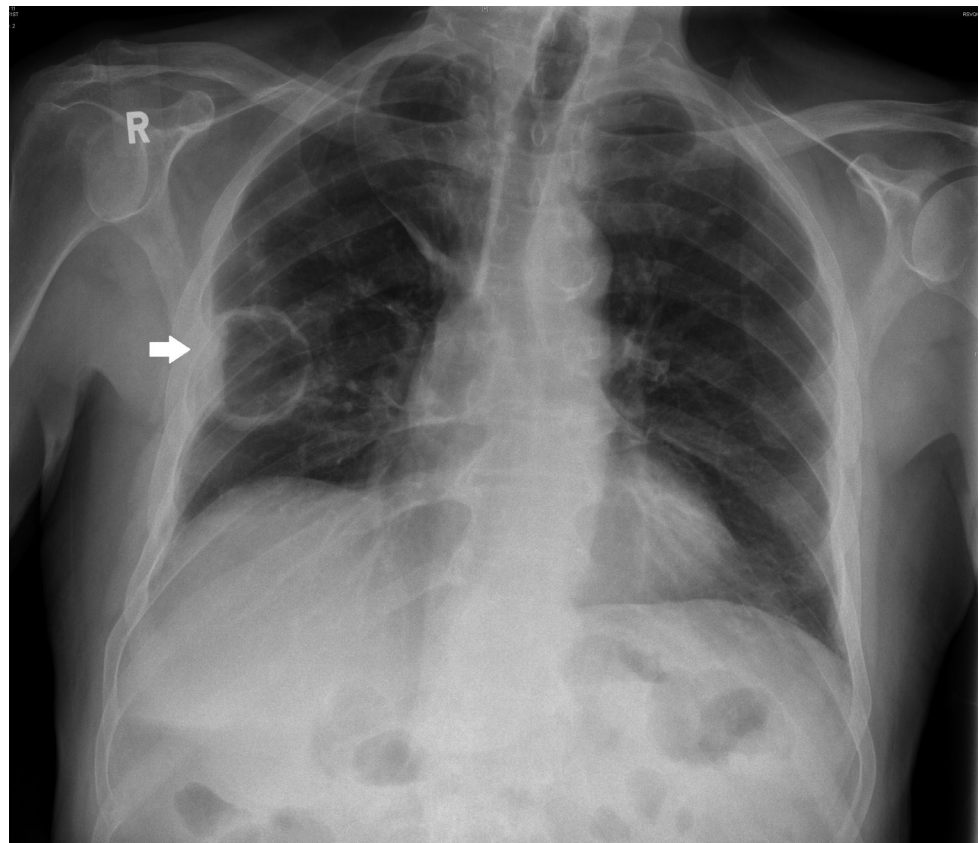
Chest radiograph showing an 'empty' lung abscess devoid of an air-fluid level.
